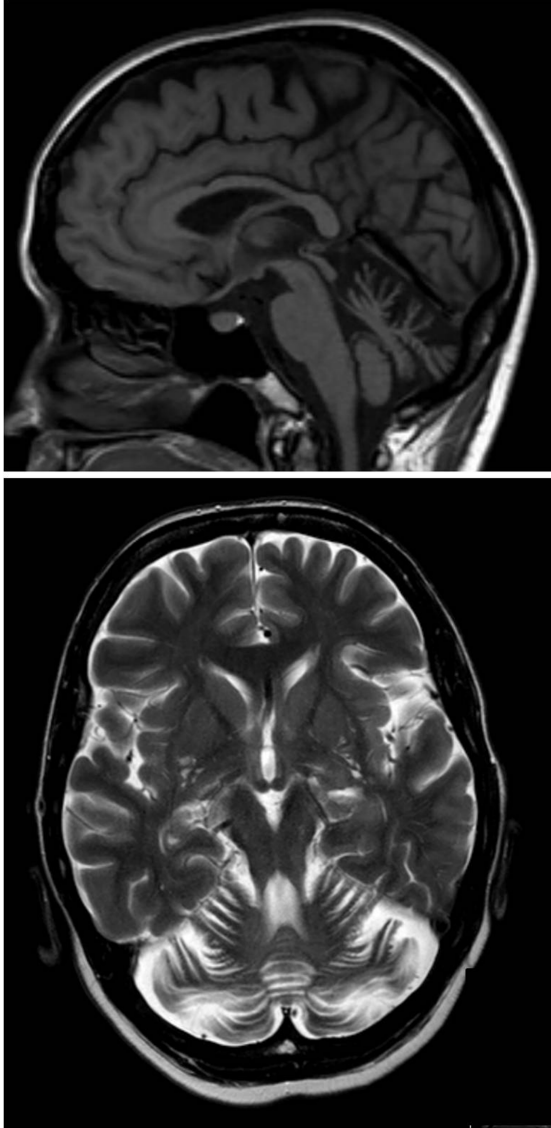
MRI of the brain of patient B. Sagittal T1-weighted (top) and transversal T2-weighted (bottom) show diffuse cerebellar atrophy.
